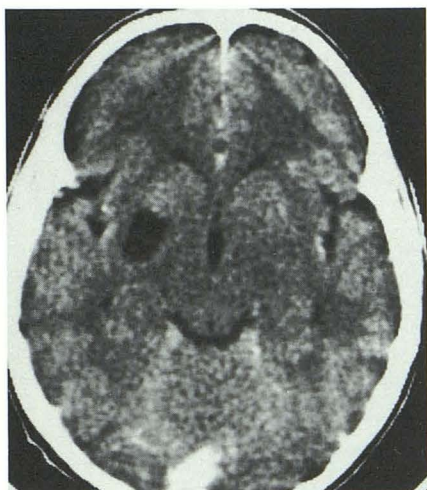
Hunter disease; axial CT: there is a circumscribed, well-defined region of CSF density in the right lentiform nucleus, consistent with a distended Virchow-Robin space.
